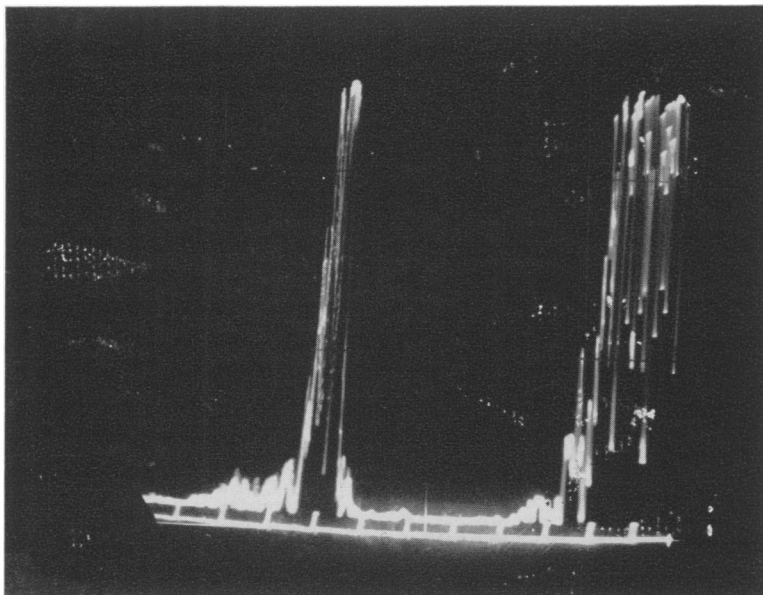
Typical ultrasound pattern of pleural fluid. The width of the echo-free zone in the center of the scan is linearly related to the width of the fluid layer overlying the lung. The echoes to the left of this zone represent normal underlying lung; the echoes to the right represent chest wall reflections.
